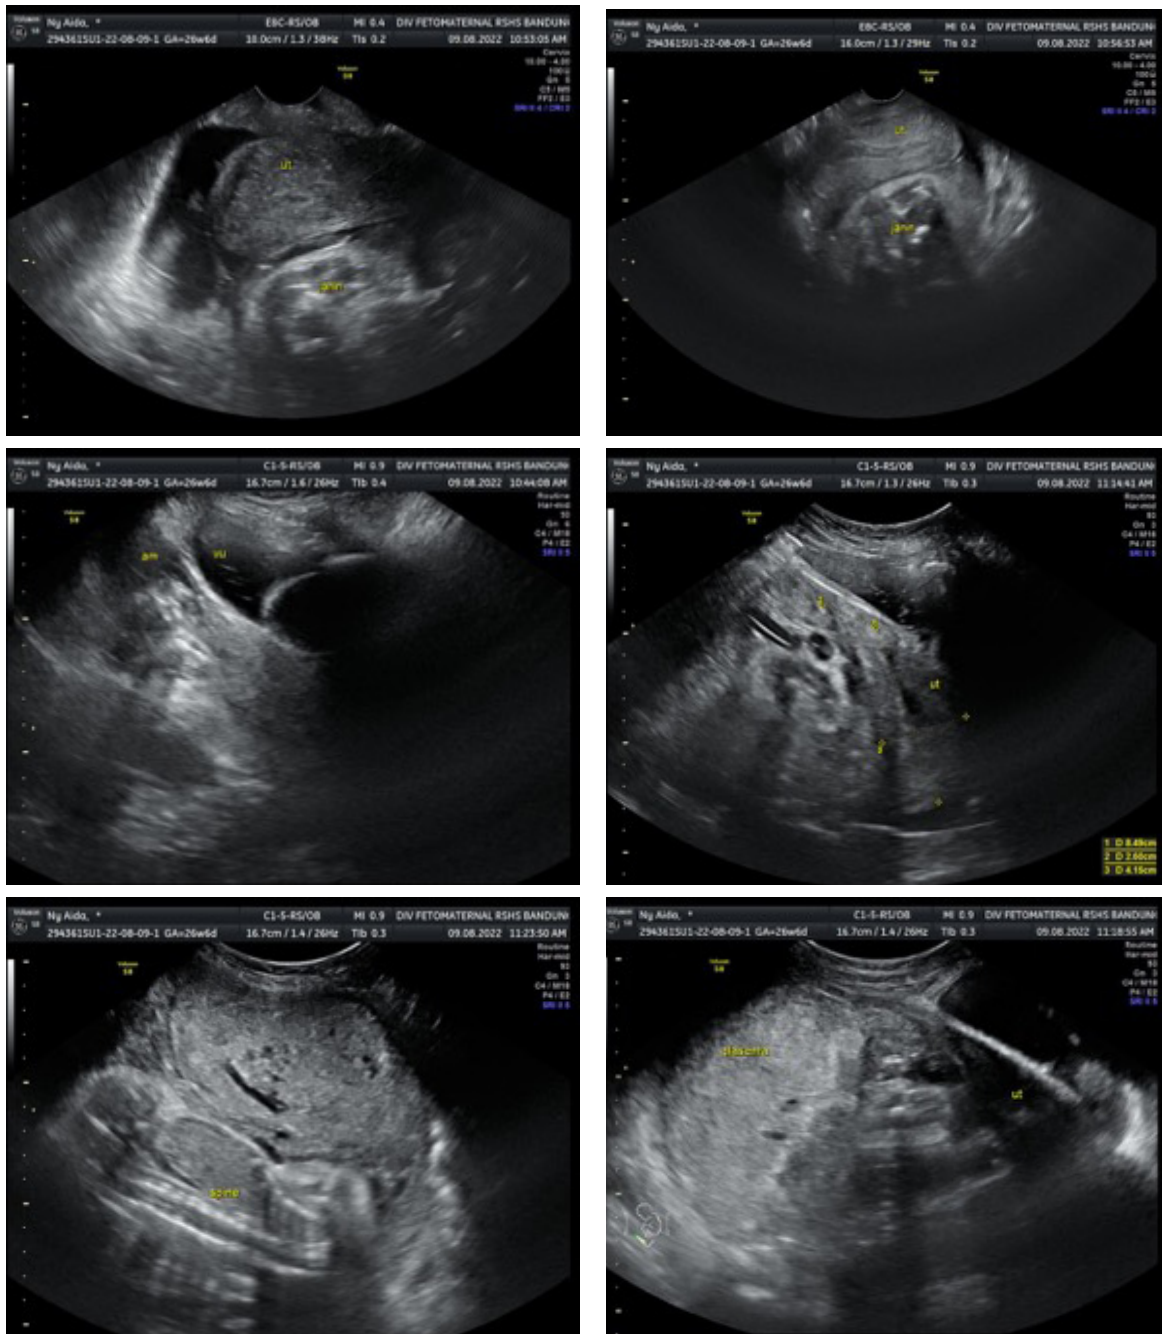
Fetomaternal Ultrasound Gestational Component Found Outside of the Uterus
